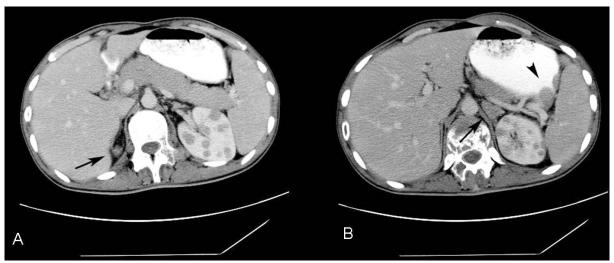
Contrast-enhanced CT scan adrenal glands demonstrates is small-low density lesions in the adrenal glands bilaterally (black arrows). There are also polypoid lesions in the stomach (arrowhead).
